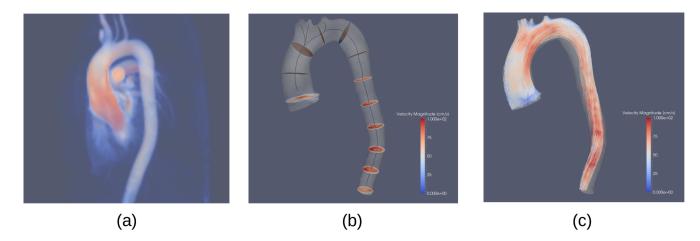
4D flow MRI of the thoracic aorta. (a) Volume rendering of the PC-MRA dataset. (b) Visualization of the segmented aortic wall and velocities on 2D planes distributed along the vessel centerline. (c) Visualization of 3D particle traces.
